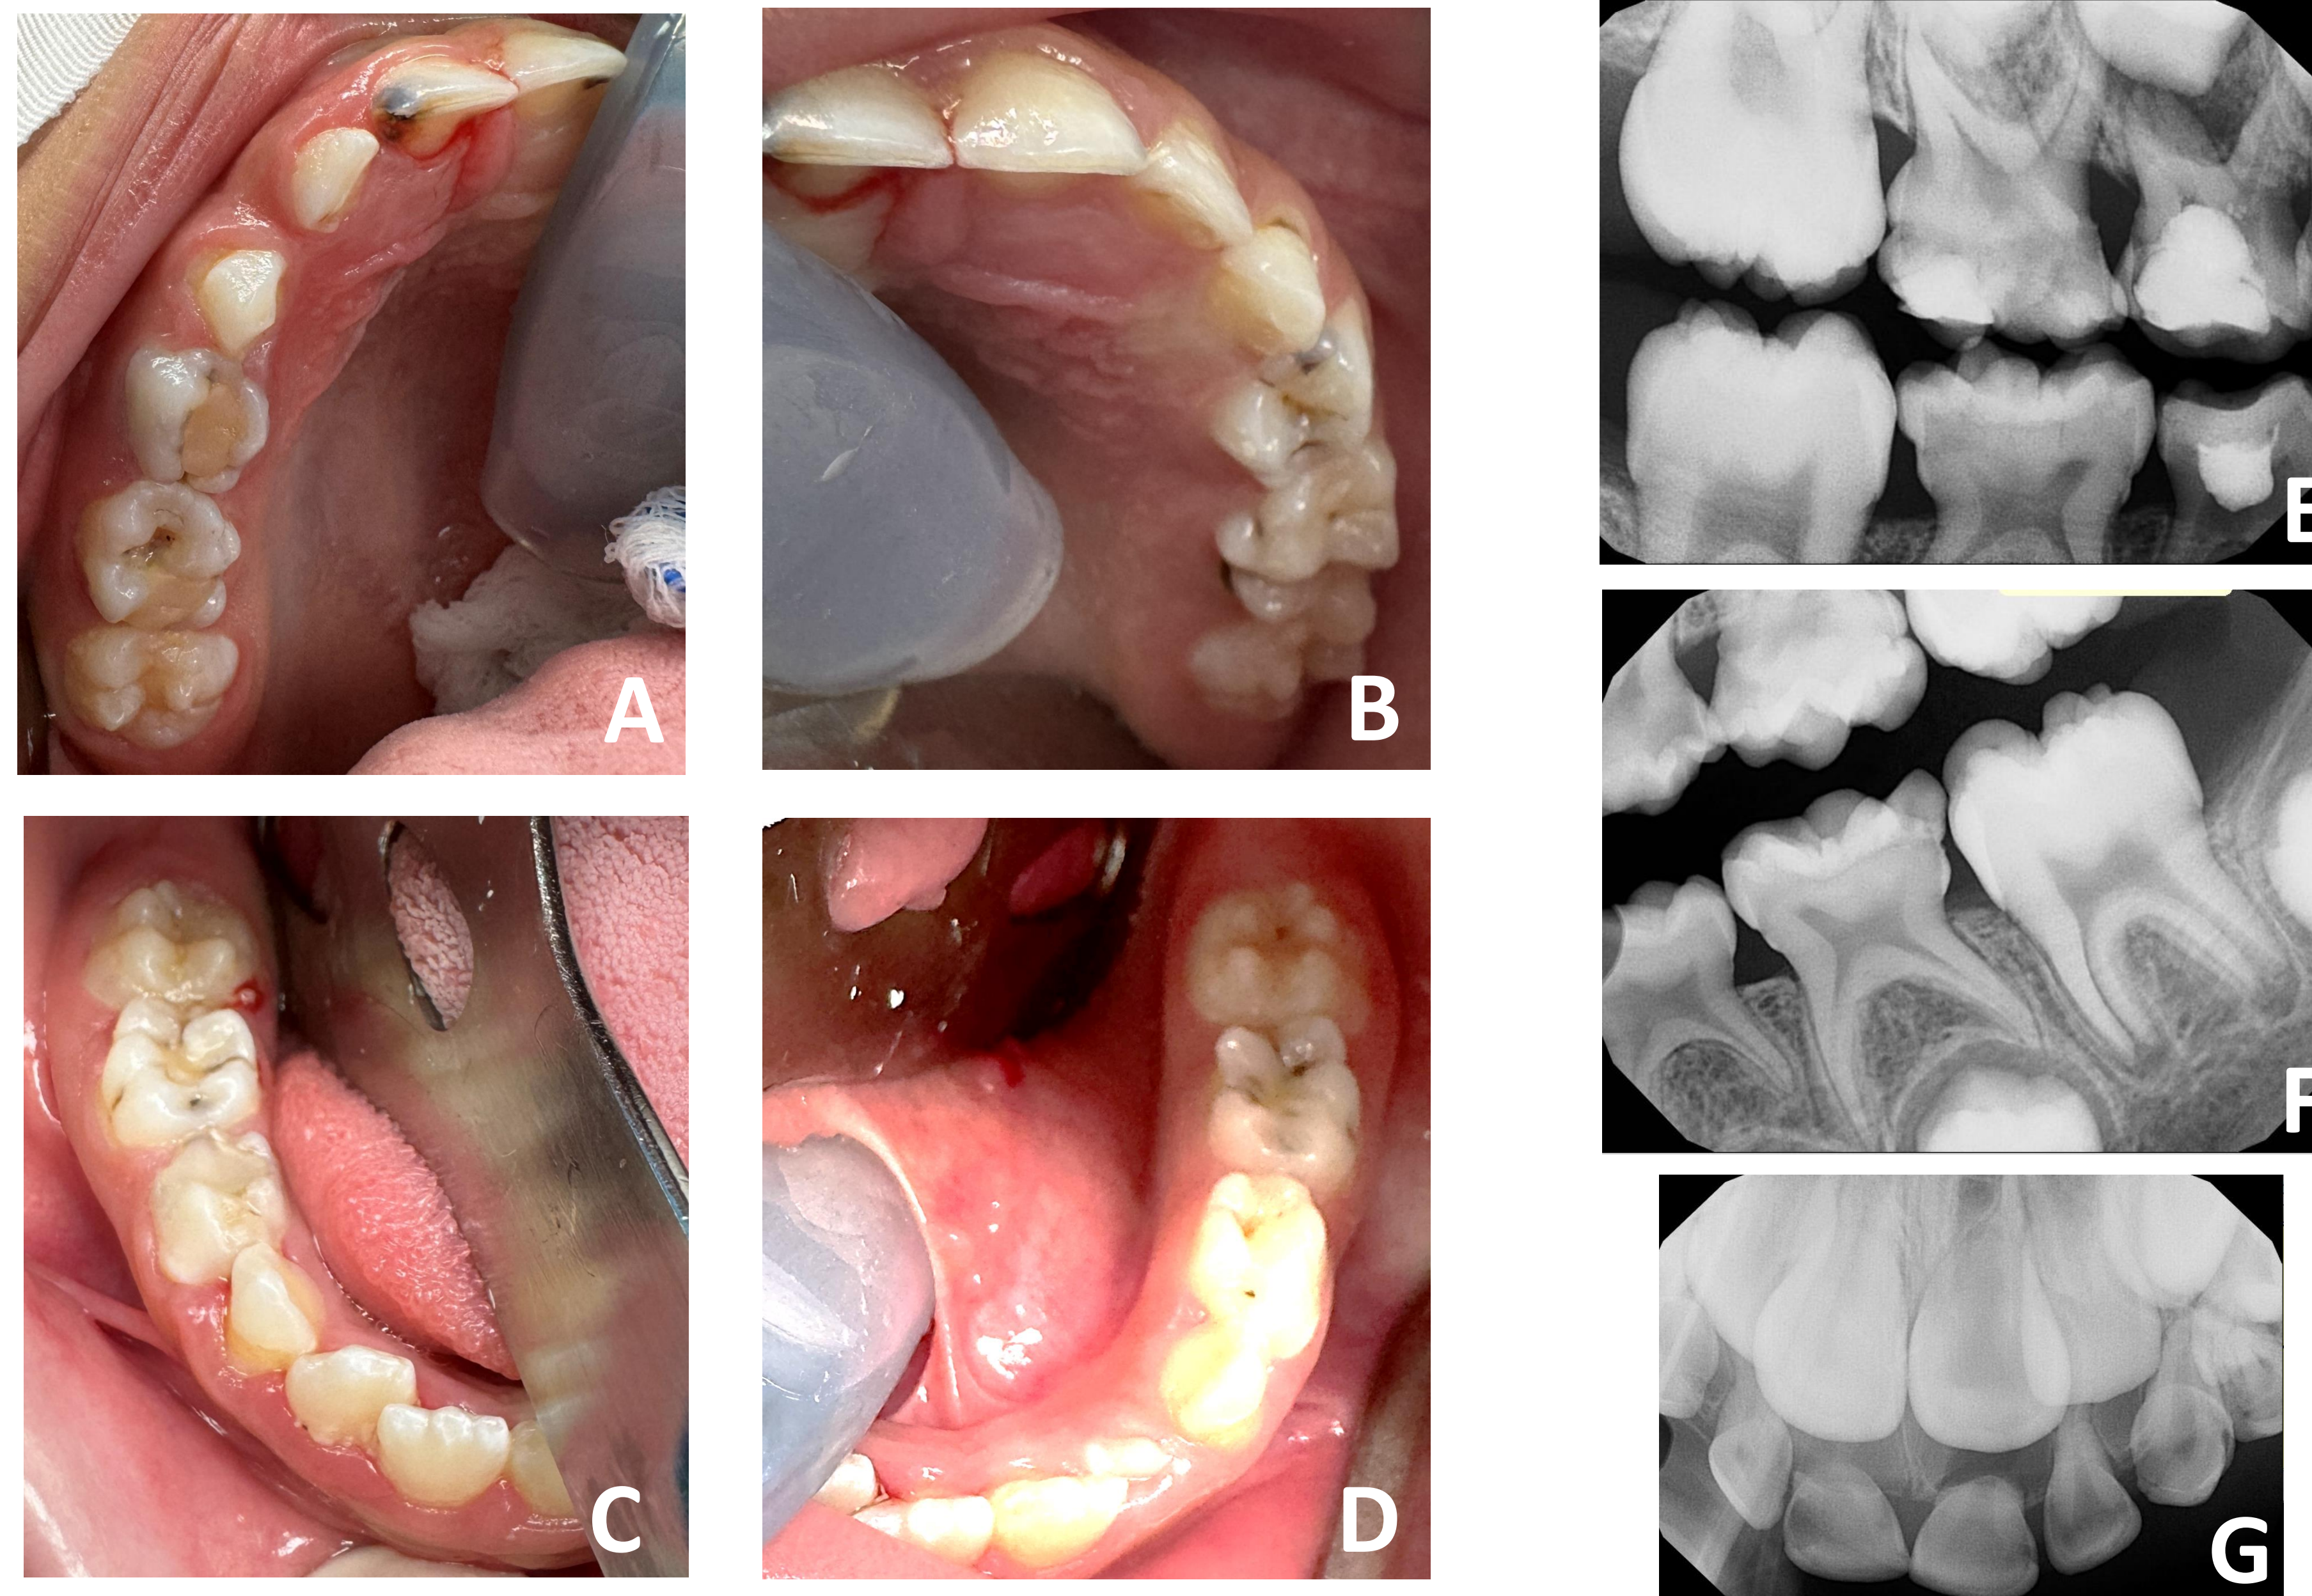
Clinical photos (A-D) and intraoral radiographs (E-G) taken day of surgery June 2024. Mulberry appearance of primary molars and cuspal constrictures of permanent first molars are able to be visualized in these images.
